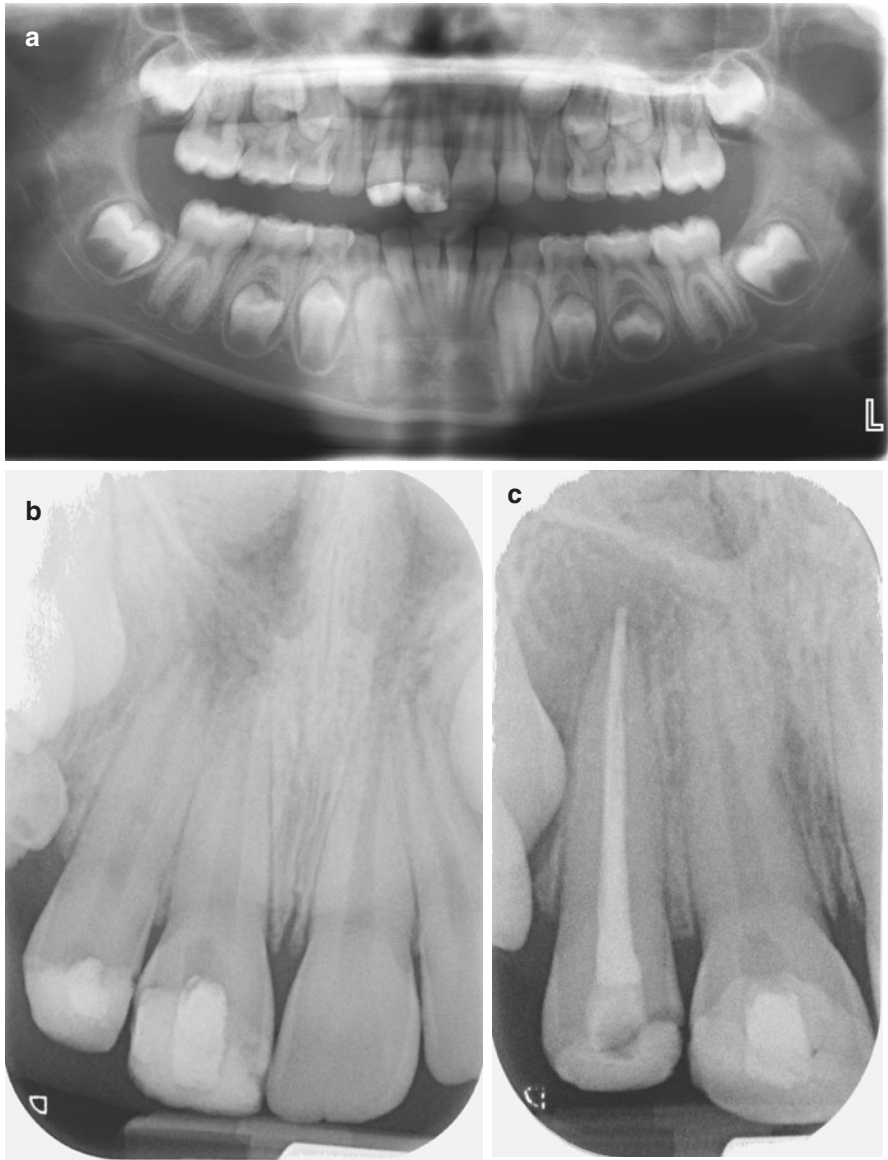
Complicated enamel-dentine fracture involving the UR1 and UR2 in an 8-year-old. Pretreatment radiographic appearance (a), Cvek pulpotomy of the UR1 (b) and apexification using mineral trioxide aggregate (MTA), backfill obturation using gutta percha and coronal seal of the UR2 (c)
